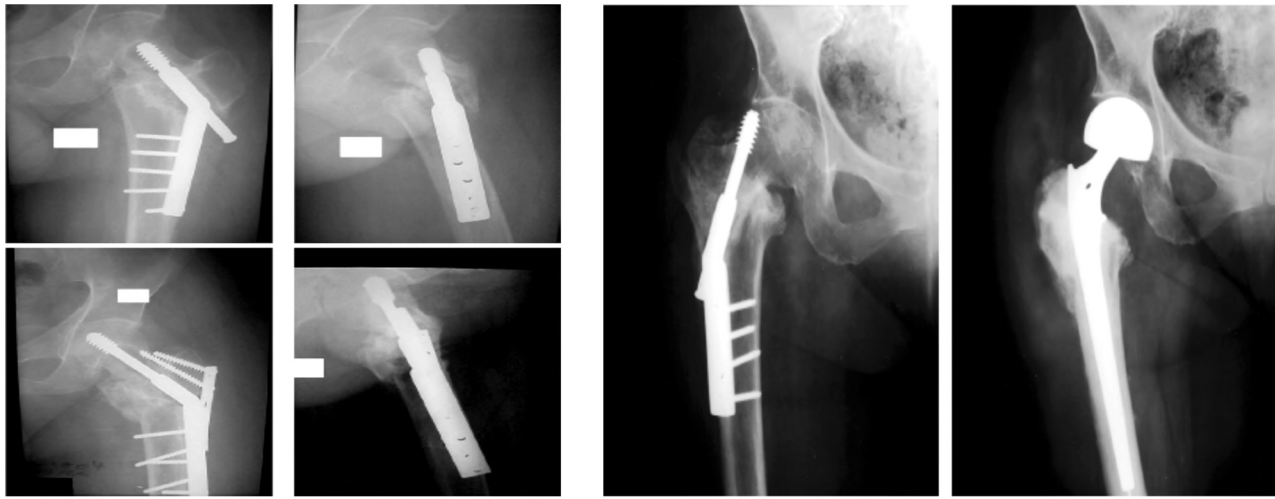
(A): Anteroposterior and lateral radiographs of a 38-year-old man showing successful union after revision of internal fixation of a failed primary fixation. (B): Anteroposterior radiographs of a 77 year-old woman with a cemented calcar-replacement bipolar prosthesis done for a nonunion and failed fixation of an intertrochanteric fracture.
